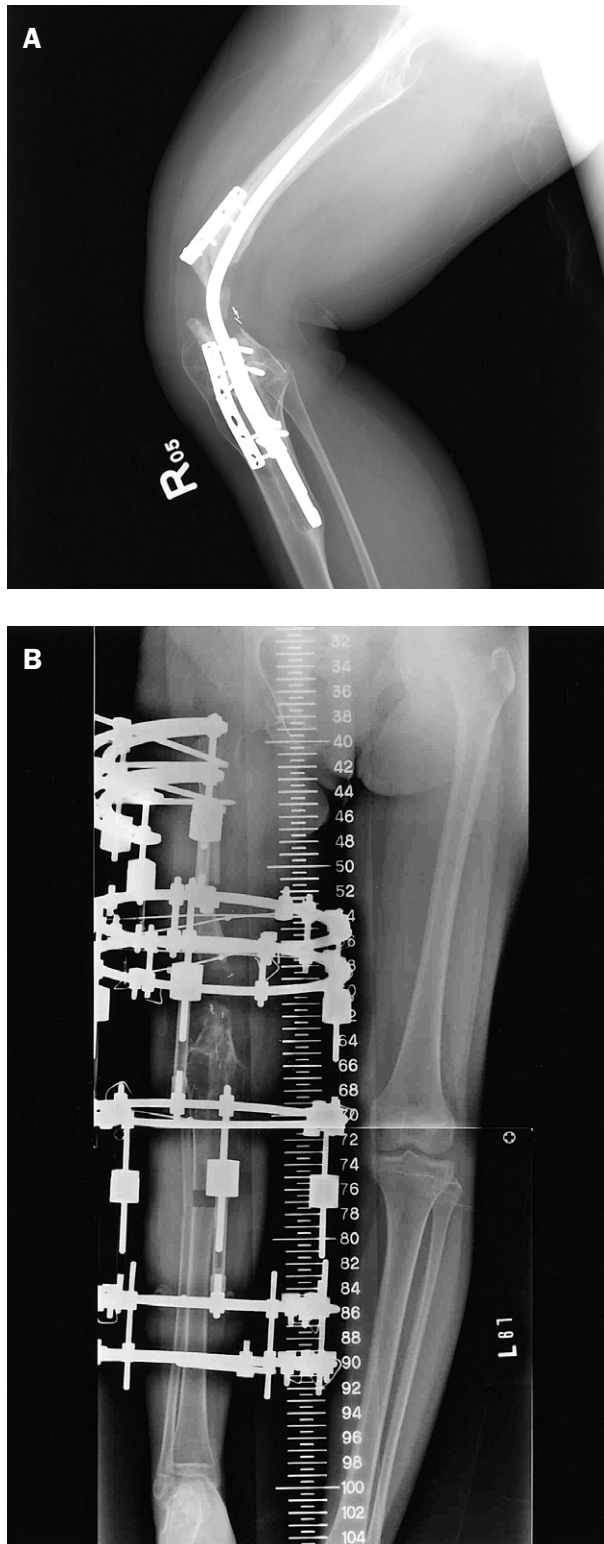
A 7-year-old girl with left distal femur osteosarcoma was treated with resection–arthrodesis and allograft reconstruction. (A) At the 7-year postoperative follow-up, an X-ray shows that the nail has angulated to 90°; the patient was in severe pain. (B) The immediate postoperative X-ray shows that the previous allograft and hardware have been removed, correcting the angulation and lengthening with Ilizarov external fixators.
